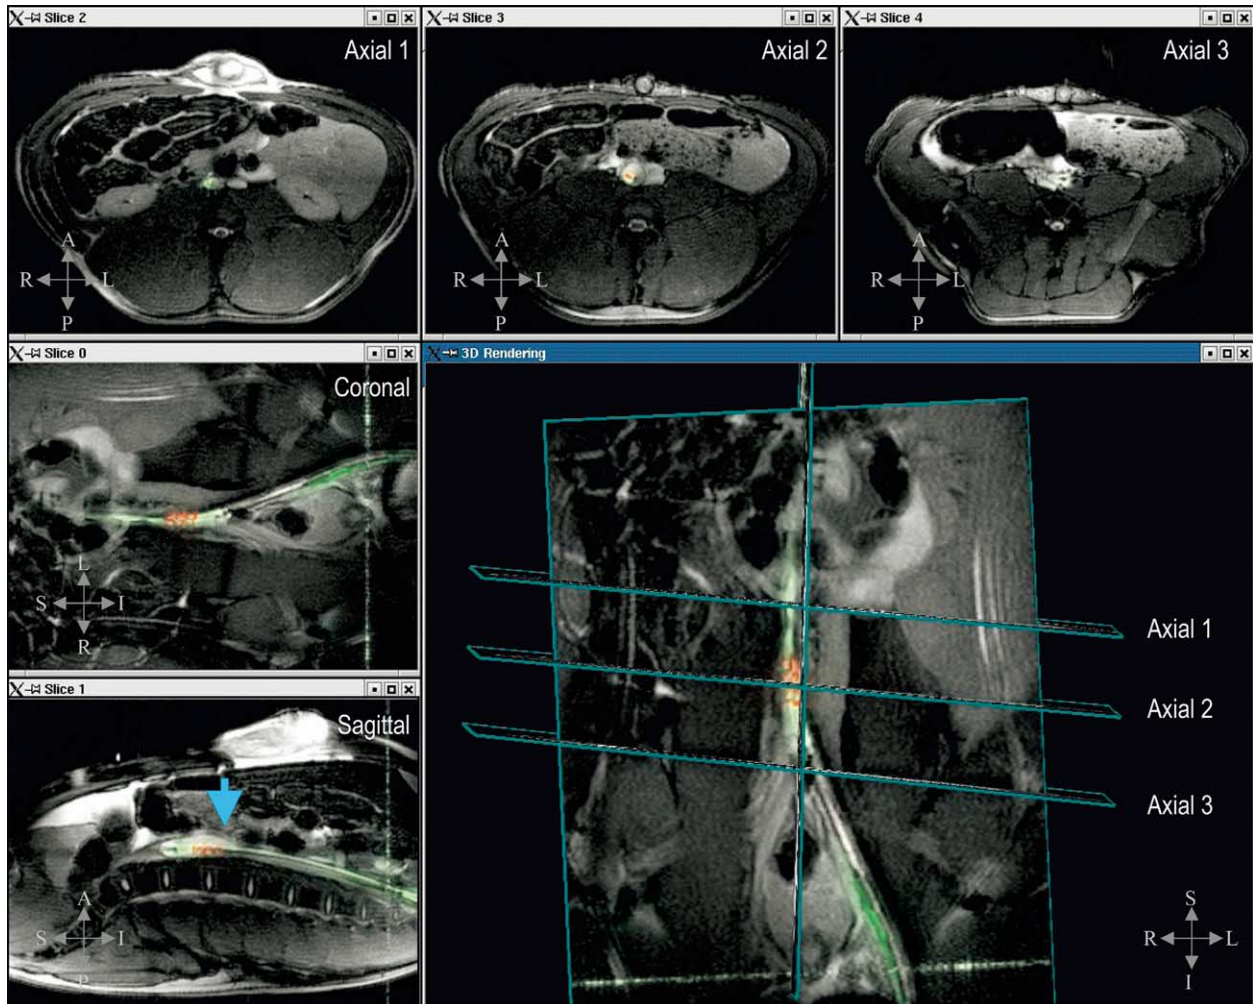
Real-time multislice imaging and three-dimensional rendering during endograft positioning. In the left column, real-time magnetic resonance imaging multislice axial, sagittal, and coronal images shown simultaneously facilitate precise device positioning. Concomitant three-dimensional rendering on the right integrates multislice information. Positioning three axial slices at the caudal renal artery origin, the middle of the aneurysm, and the aortic bifurcation, respectively, allows simultaneous capture of the most important anatomy for device placement. The coronal and sagittal slices provide an overall “bird’s eye” view of the aorta. Orientation markers indicate: S = superior, I = inferior, A = anterior, P = posterior, R = right, L = left. Blue arrow indicates aneurysm.
